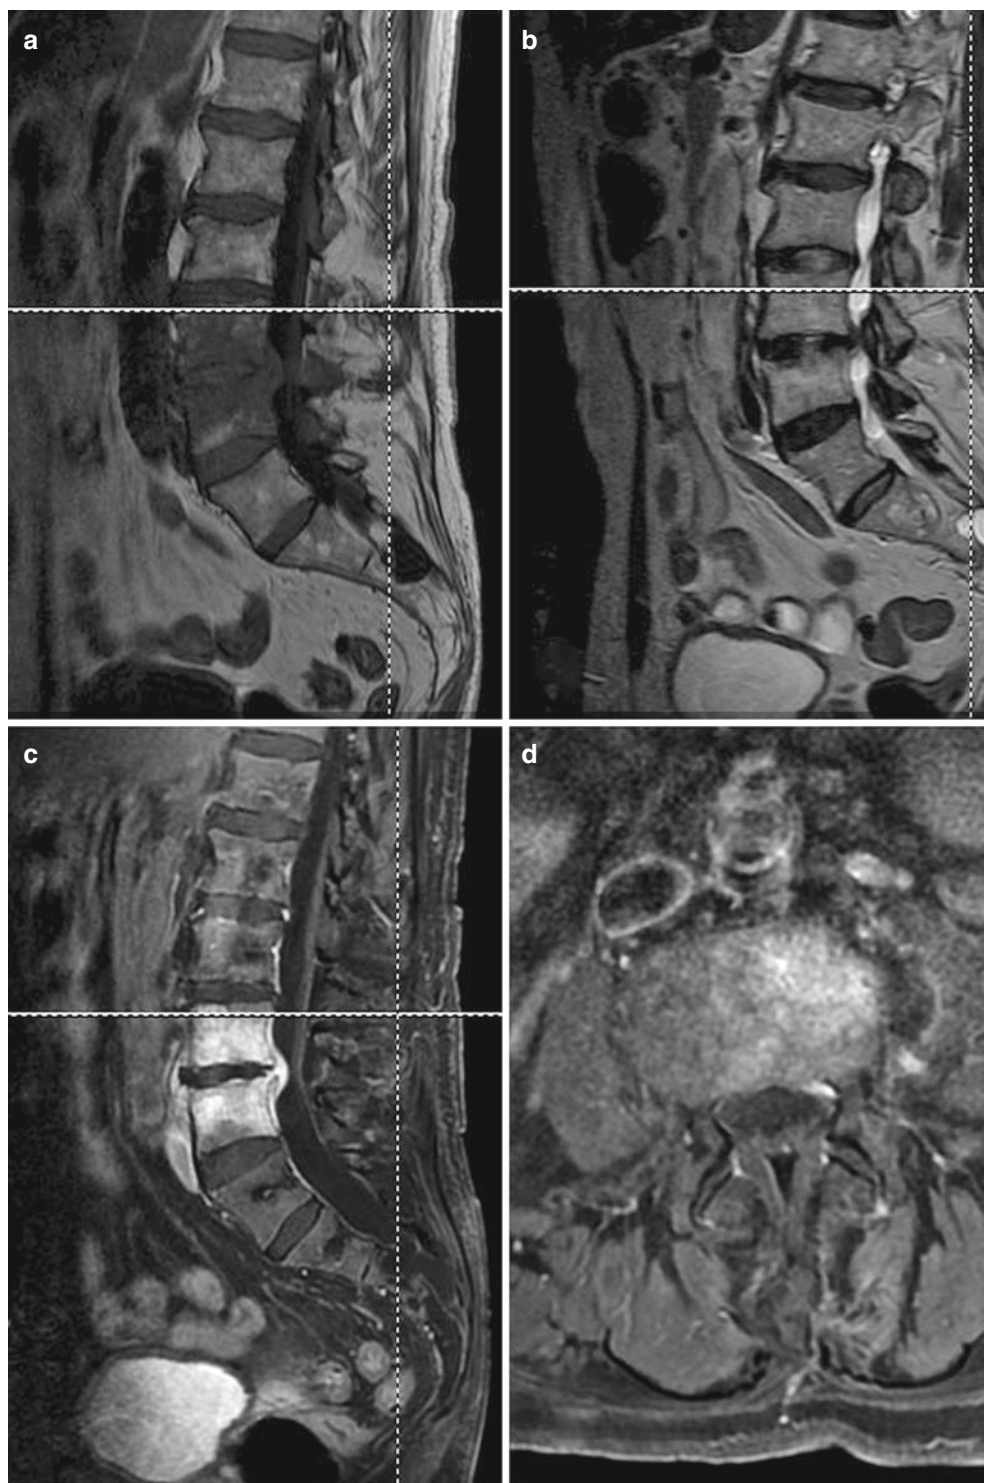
MRI study of lumbar spondylodiscitis: sagittal T1W FSE (a) and sagittal T2W FRFSE (b) scans; sagittal T1W FSE (c) and axial T1W FSE (d) scans with intravenous gadolinium contrast medium
